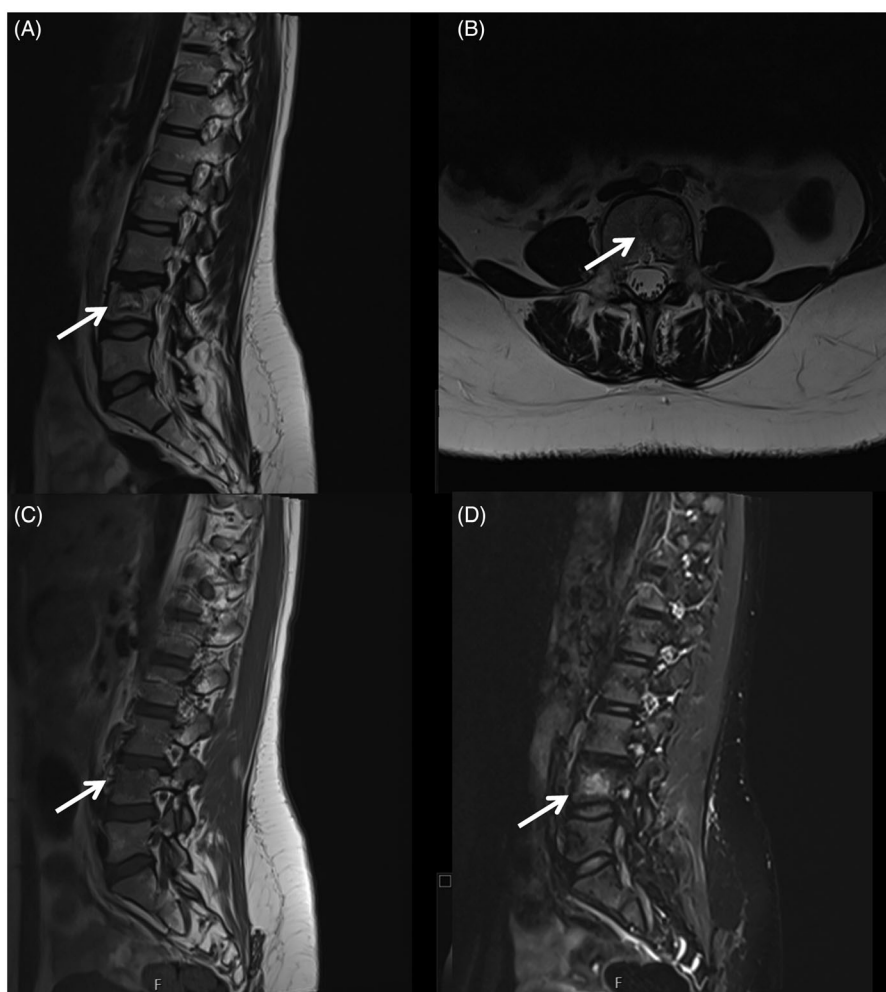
MRI at follow up- 16 months after the diagnosis. (A) This is a sagittal T2W MRI image showing the L4 hyperintense lesion (arrow), the size is smaller when compared to [Figure 1\(A\)](#). (B) This is an axial T2W MRI image at the level of L4 demonstrating the lesion that had reduced in size and no surrounding bone oedema (arrow). (C) This is a sagittal T1W MRI image showing a smaller L4 lesion with intermediate intensity (arrow). (D) This is a sagittal STIR MRI image showing the L4 hyperintense lesion that had reduced in size (arrow).
